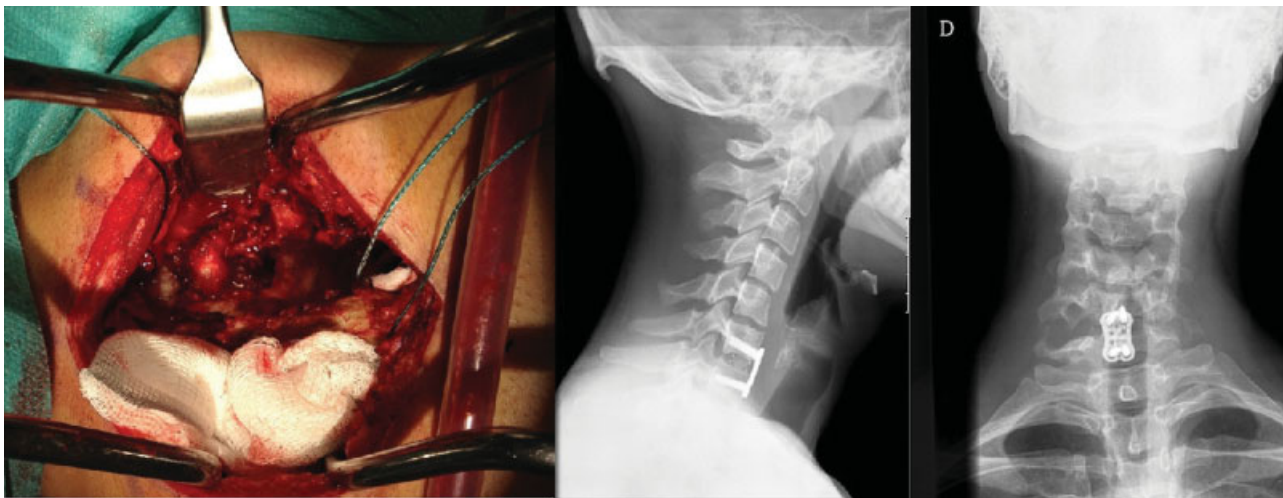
Left: intraoperative picture of tumor resection; right: postoperative X-ray (lateral view and AP).
